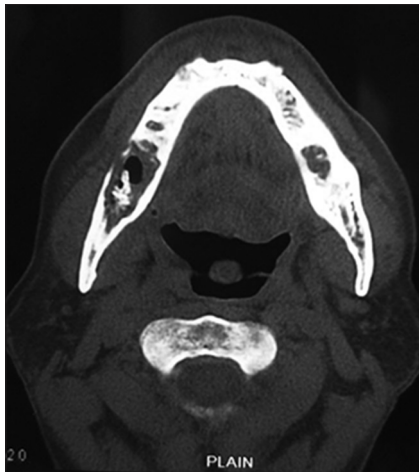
Case 3 - CT image, axial section
